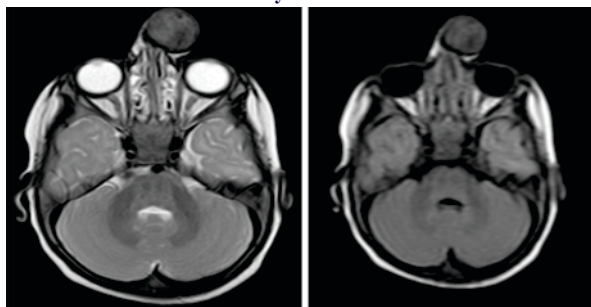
And 3c Axial T2 And FLAIR Image Of Brain Showing The Extranasal Lesion Is Isointense To Grey Matter
